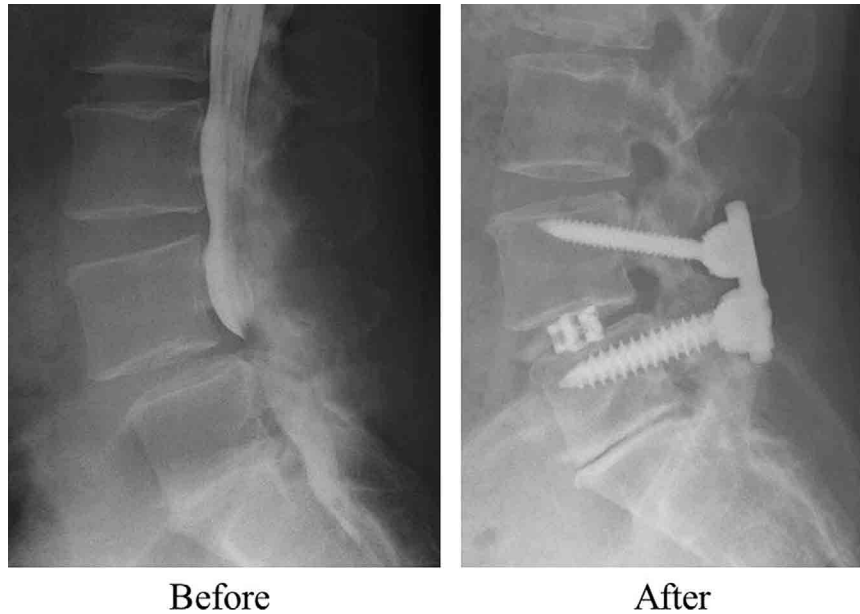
Lumbar myelography and plain lateral X-ray 2 years after fusion surgery. Transforaminal lumbar interbody fusion (TLIF) was done using pedicle screws and an intervertebral body cage. Collapse of the disc space can be seen at L5/S1. Left panel : lumbar myelography before TLIF showed lumbar spinal canal stenosis at L4/5 due to L4 spondylolisthesis. Right panel ; Two years after TLIF. There was no screw loosening and subsidence of the cage.
